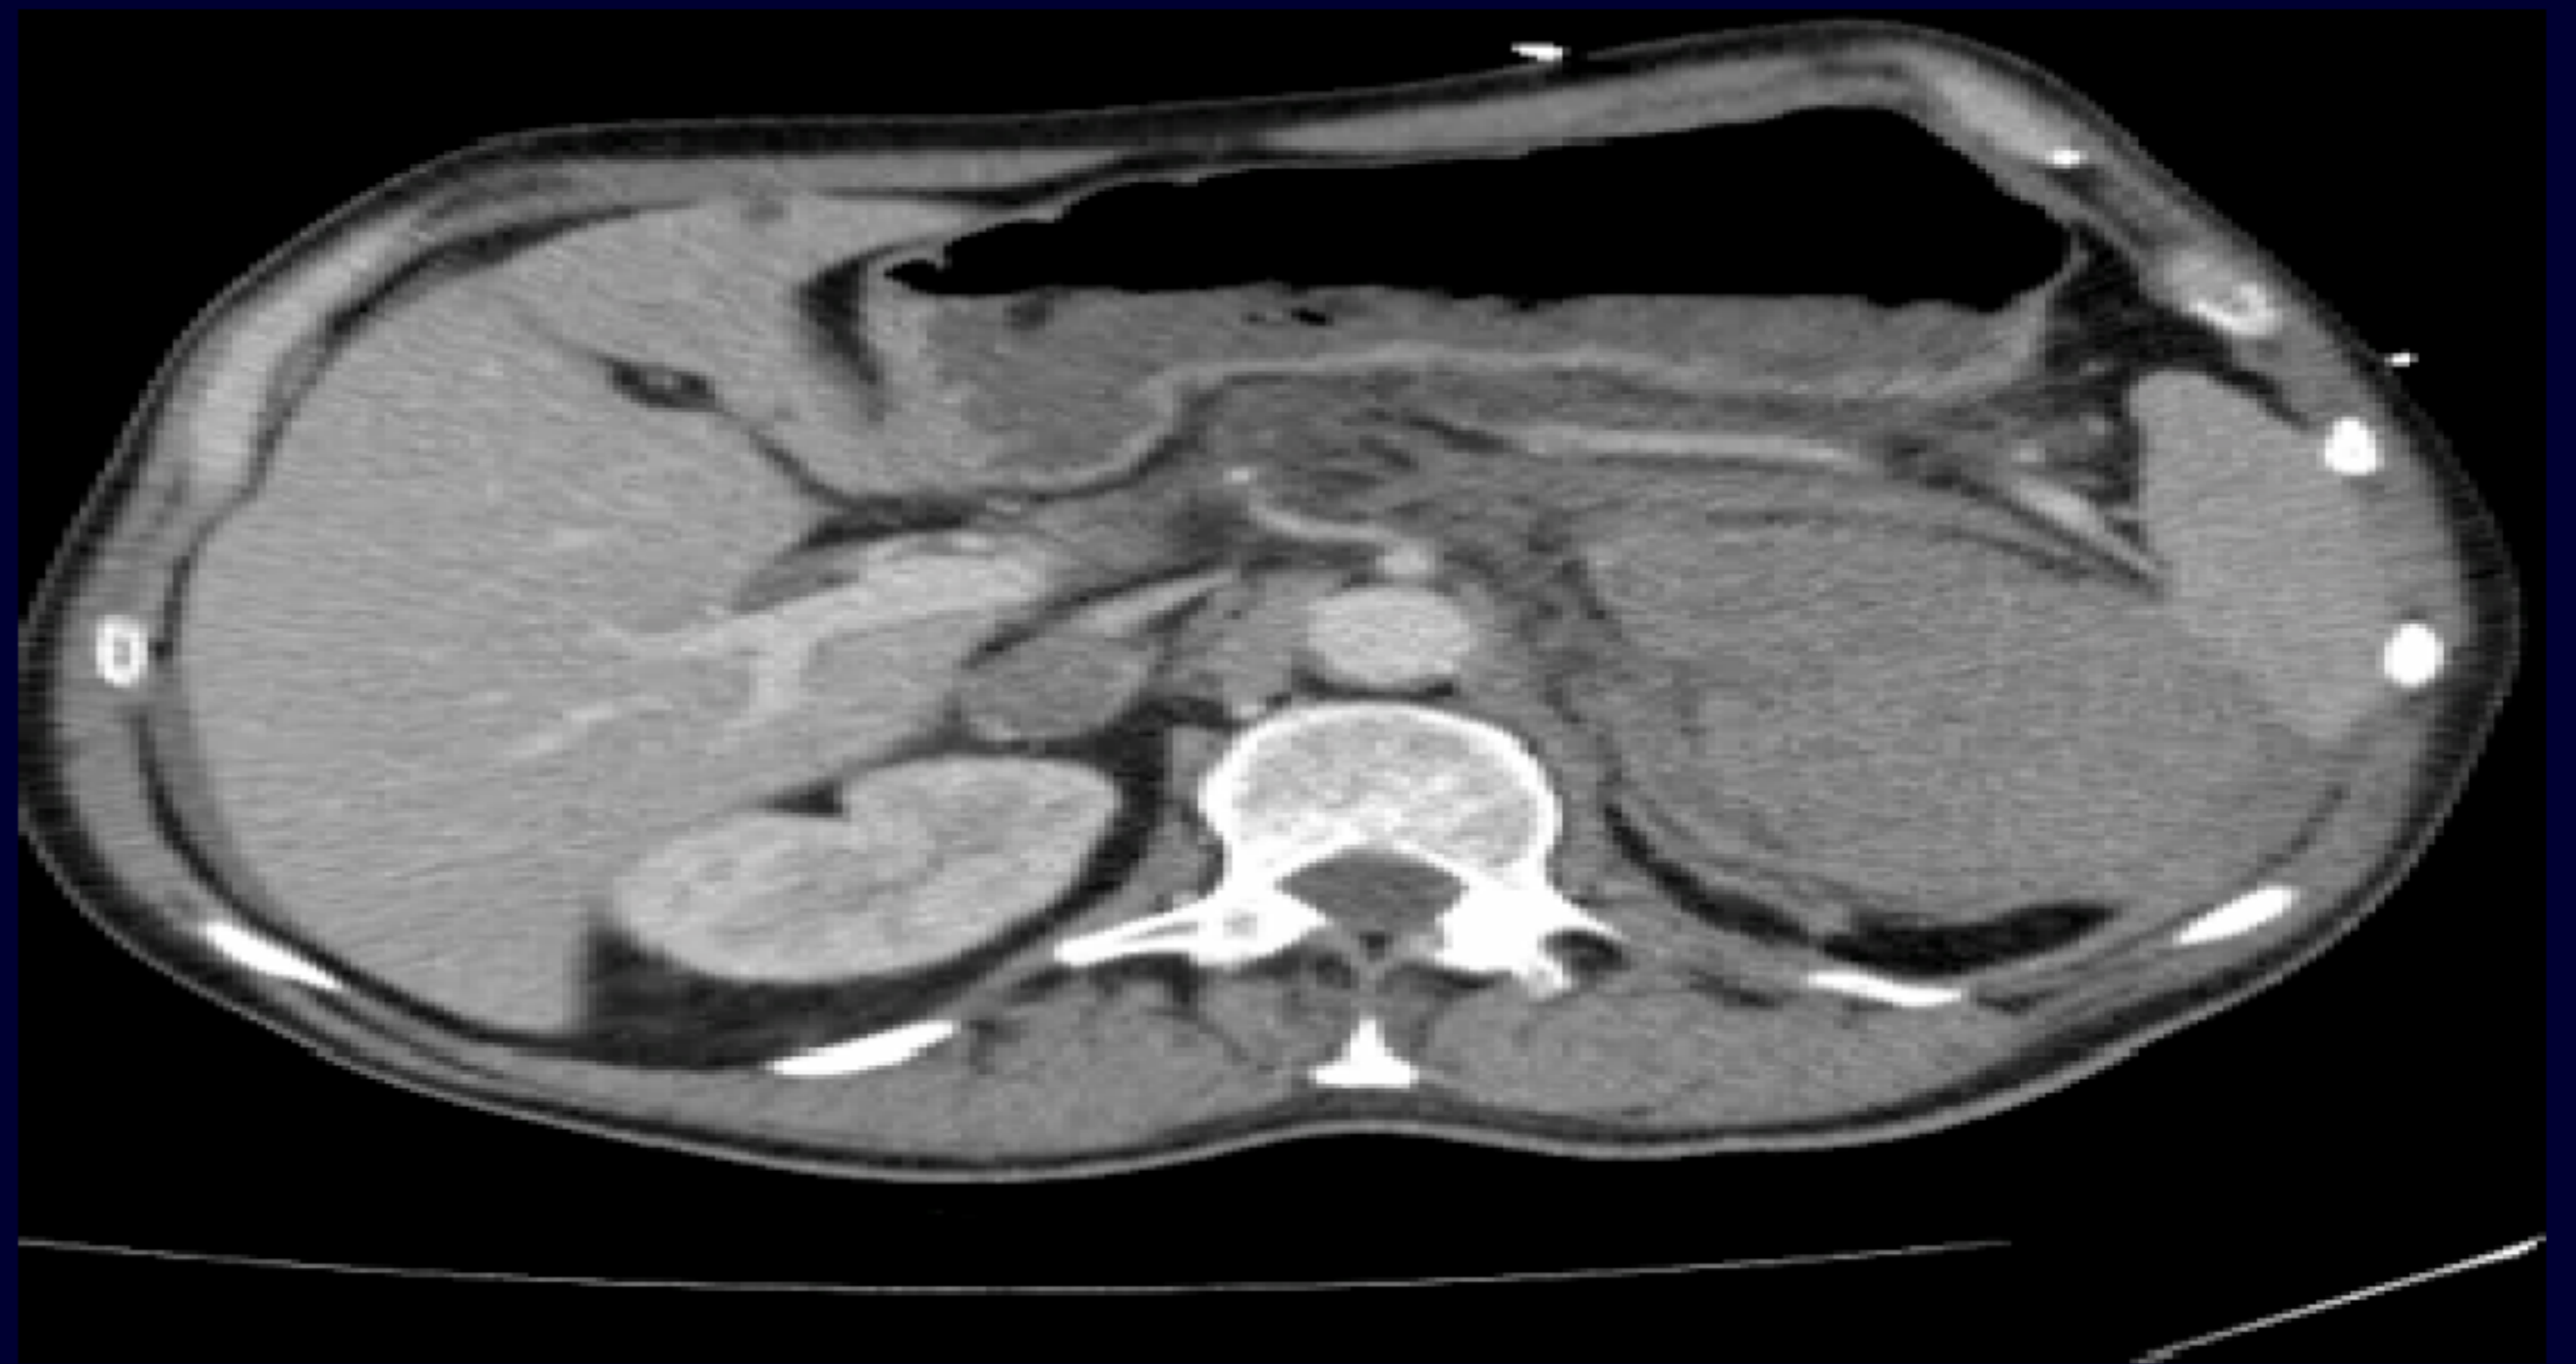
Sagittal CT abdomen shows bilateral adrenal masses measuring 12cm on the left and 2.7cm on the right with surrounding inflammatory changes consistent with a haemorrhagic left adrenal mass with retroperitoneal extension.
